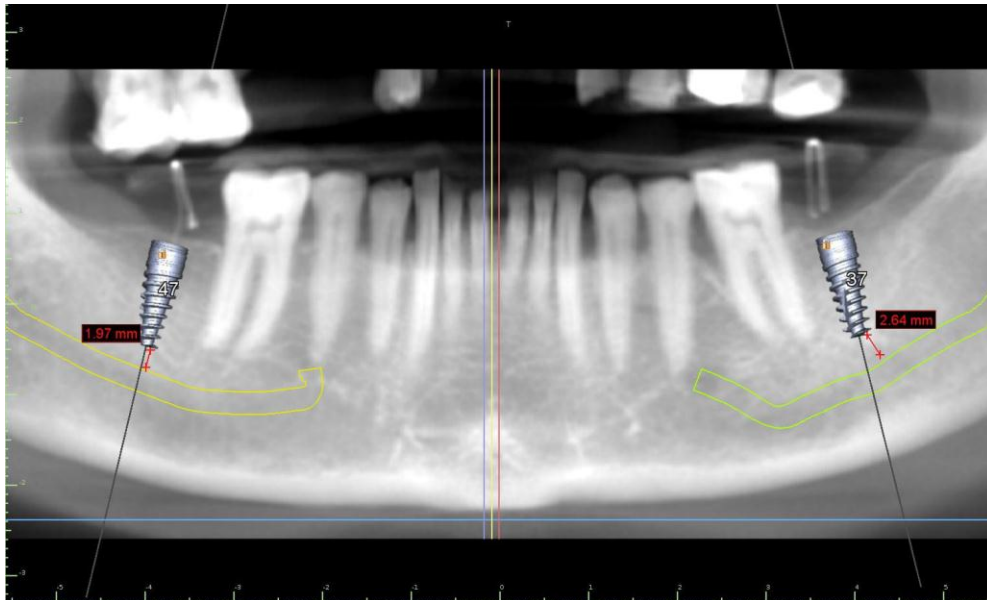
RADIOGRAPHIC MARKERS PLACED ON THE UPPER PART OF THE SPLINT.
